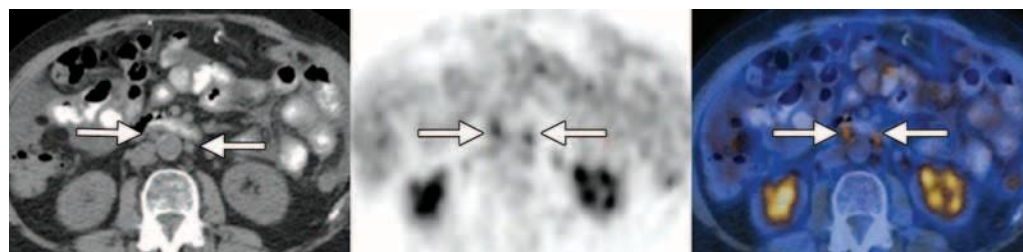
Normal-sized, FDG-avid metastatic lymph nodes in a 61-year-old woman with markedly elevated CA-125 levels and a history of TAH, BSO, omentectomy, and chemotherapy for stage IIIC serous papillary adenocarcinoma. Axial contrast-enhanced CT (left), FDG PET (middle), and fused PET/CT (right) images show increased FDG uptake
